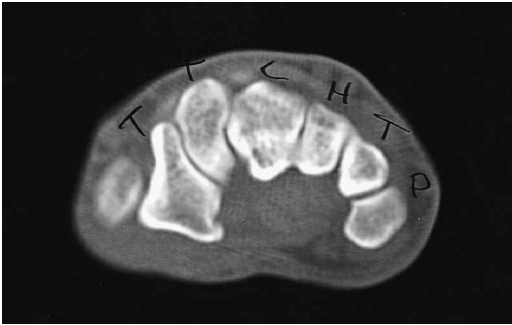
An axial CT scan confirms that the capitatum fracture has healed with no dislocation. A linear band of sclerosis is seen in the capitatum bone (c = capitatum bone).
